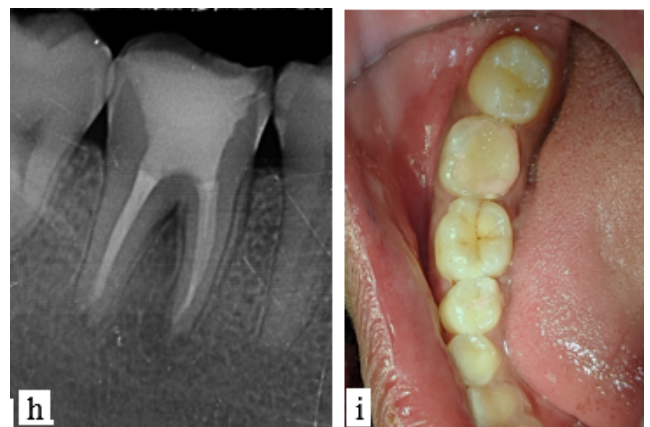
h: Radiograph showing postendodontic restoration & complete healing of healing of the periapical lesion, with evidence of bone regeneration in the furcal region; i: Intraoral clinical image showing complete elimination of sinuses
